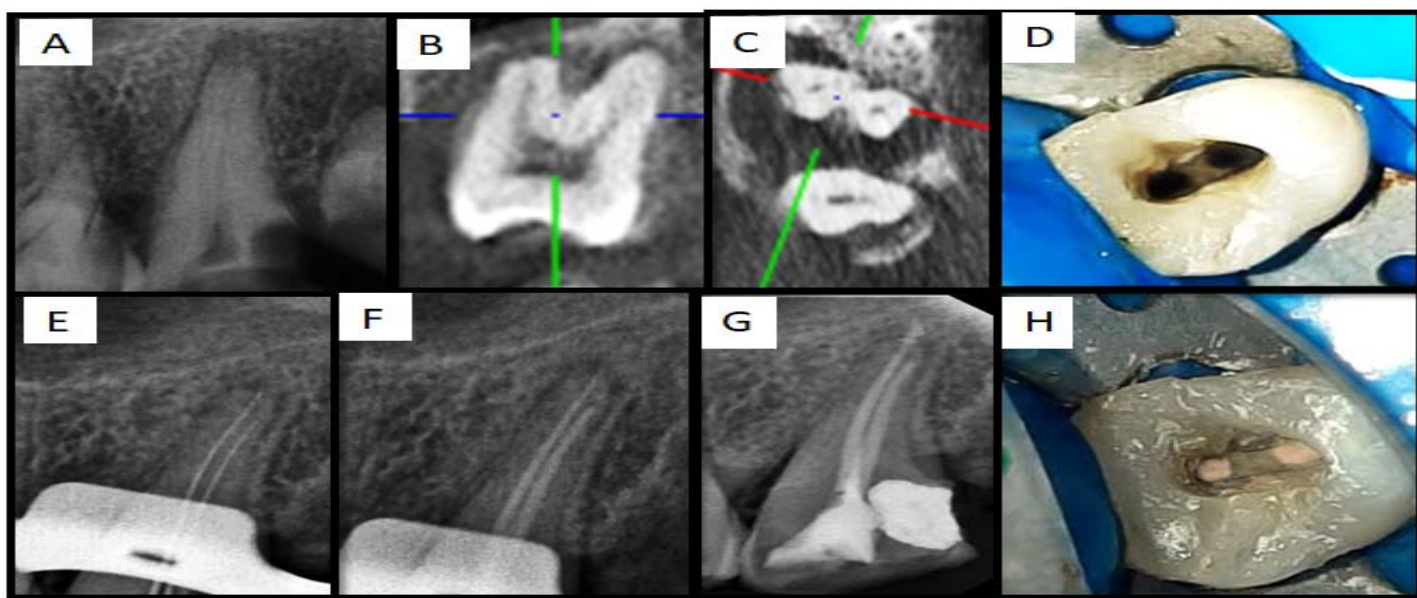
A) Preoperative Radiograph. B & C) Preoperative Coronal & Horizontal sections of CBCT Showing presence of two (Buccal & Palatal) roots of maxillary second molar. D) Access Cavity Preparation. E) Working Length Radiograph. F) Master Cone Radiograph. G) Post obturation radiograph. H) Post obturation Clinical Picture
